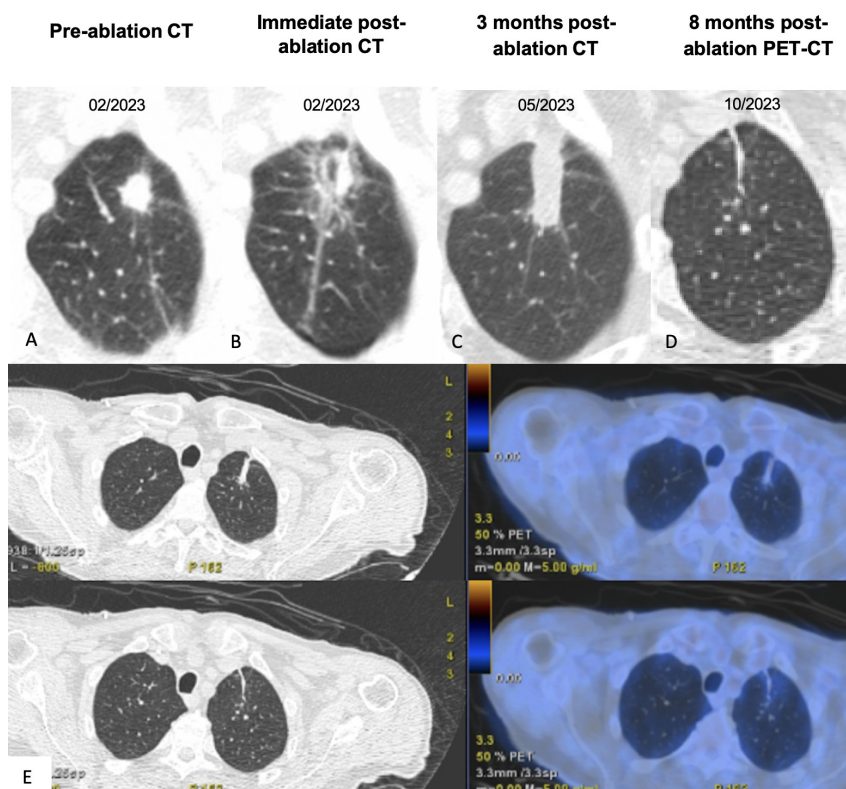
Imaging surveillance. Pre-ablation tomodesitometric examinations (Fig. 5A), immediately after ablation (Fig. 5B) and post-ablation imaging follow-up (Fig. 5C-E). PET-CT examination performed 8 months after ablation (Fig. 5D and 5E) without findings suggestive of active, loco-regional or distant, disease.
